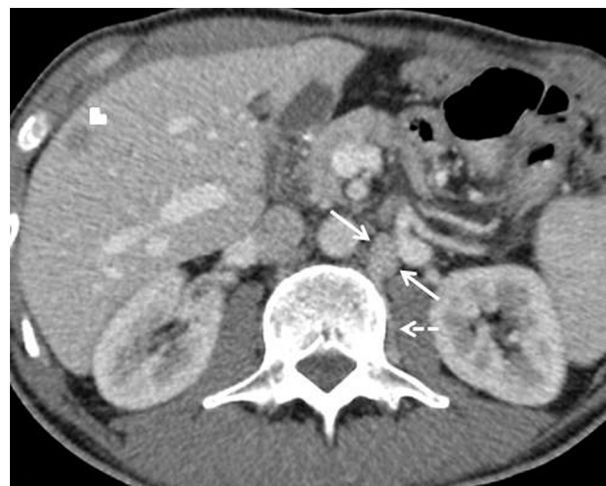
ALCV aneurysm mimicking lymphadenopathy. A 39-year-old male patient with known gastric cancer underwent a contrast-enhanced abdominal CT scan for metastasis evaluation. Axial plane CT image shows aneurysm (solid arrows) in the ALCV (dashed arrow) near the LRV inlet. Also note is made of a hypodense metastasis in the right liver lobe (arrowhead).
